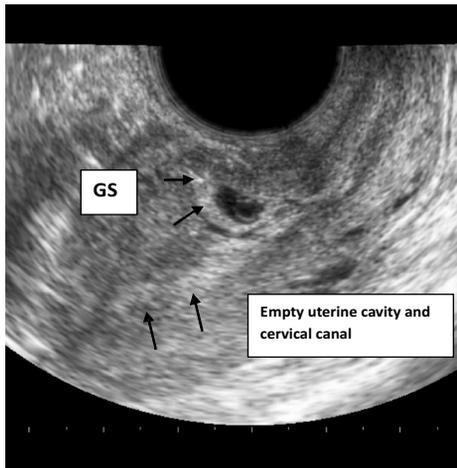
Transvaginal ultrasonography showed empty uterine cavity and cervical canal, location of gestational sac(GS) in anterior uterine wall at the level of isthmus embedded in right side of previous scar.(Transverse section)
